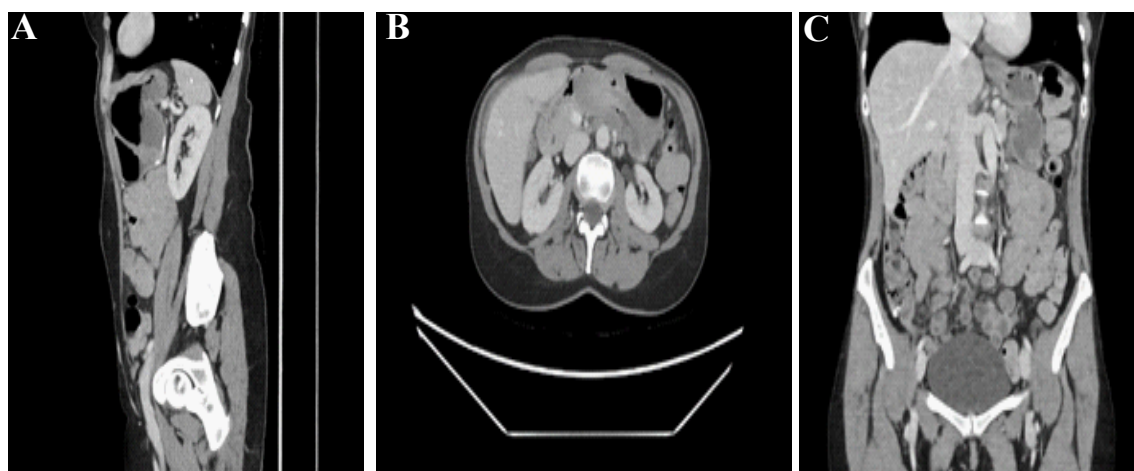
Computed tomography (CT) abdomen and pelvis with contrast showing (A) diffuse mural thickening of the gastric antrum with associated intussusception of the gastric body extending into the gastric antrum (B) Coronal view, (C) sagittal view.
